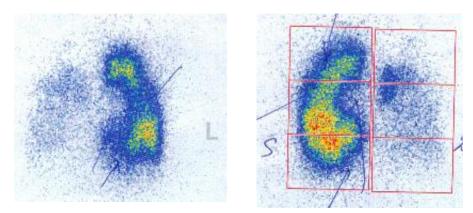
Pulmonary scintigraphy in children with cystic fibrosis. Absent perfusion in pulmonary sectors of the lung
